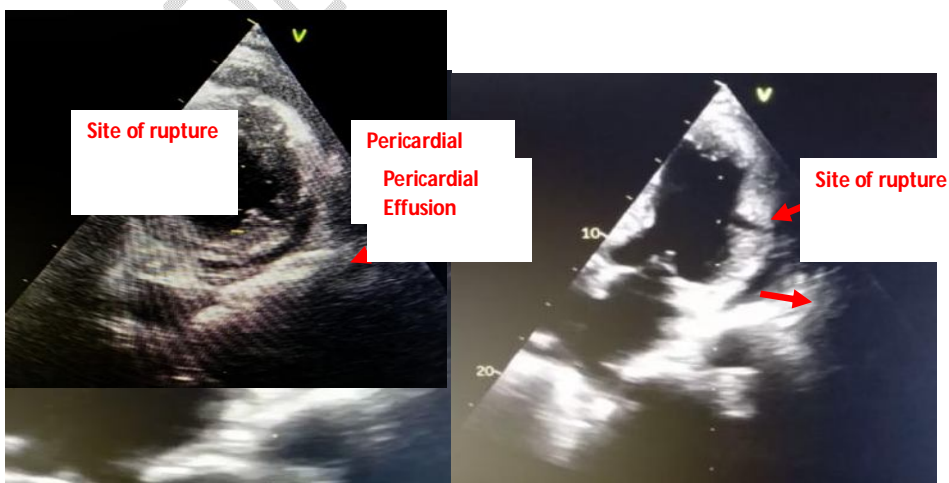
transthoracic echocardiography : myocardial defect * in the anterolateral wall , with a serpiginous pattern , associated with pericardial effusion
